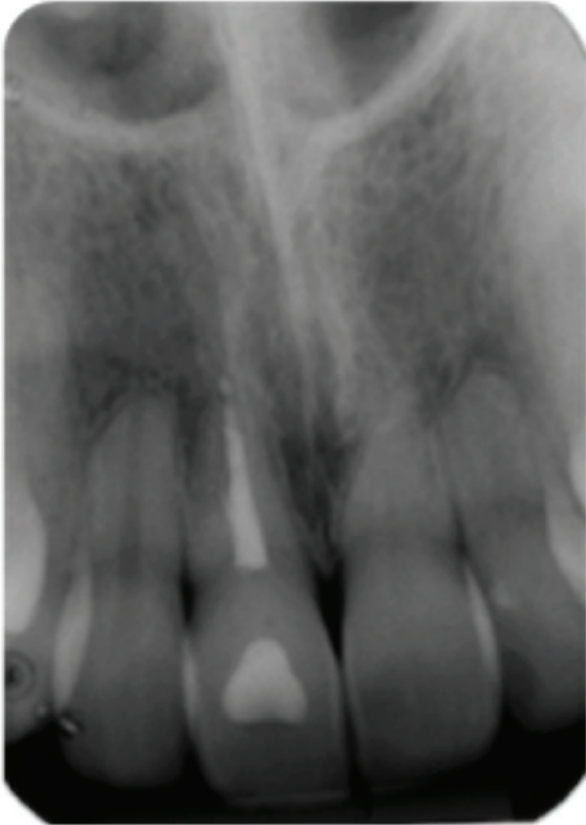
10-year periapical radiograph follow-up.
